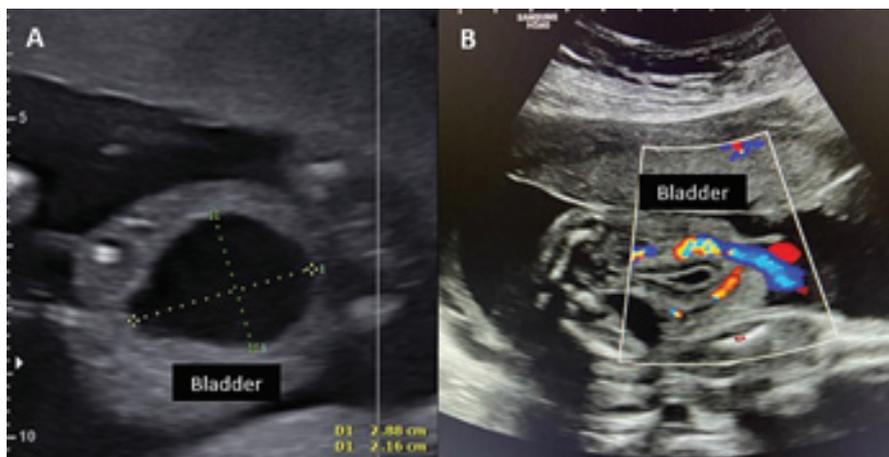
Ultrasound in the axial plane showing the fetal bladder 3 days (A) and 7 days (B) after laser fulguration of the posterior urethral valves. There was normalization of the amniotic fluid volume and reduction of the bladder size.
